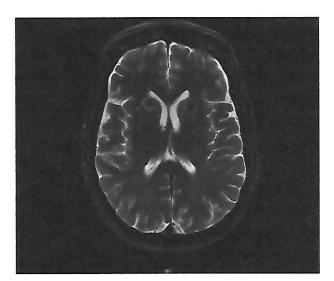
Magnetic resonance imaging of the first patient with cryptococcal infection and AIDS showed areas of hyperintensity in white matter, predominantly in the caudate and lenticular nucleus (T2 sequence). There were no pathological findings in the cerebellopontine angle. Also, no reinforcement was found with gadolinium contrast. Asterisks represent the areas of hyperintensity in the white matter due to cryptococcal infection.
